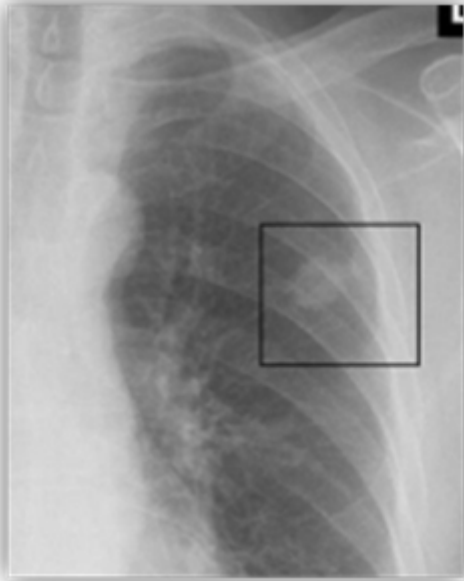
Cancer blob on x-ray image [10.]
